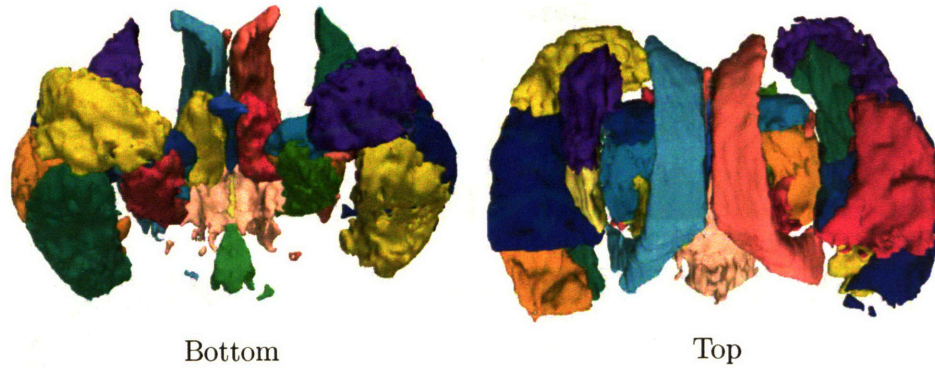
The images show an automatic segmentation of brain MR images into 31 anatomical structures. The segmentation is guided by an anatomical tree, which partitions the segmentation problem into four levels (see Figure 5-5.) This partition reduces the complexity of the segmentation problem by dividing it into simpler subproblems.
